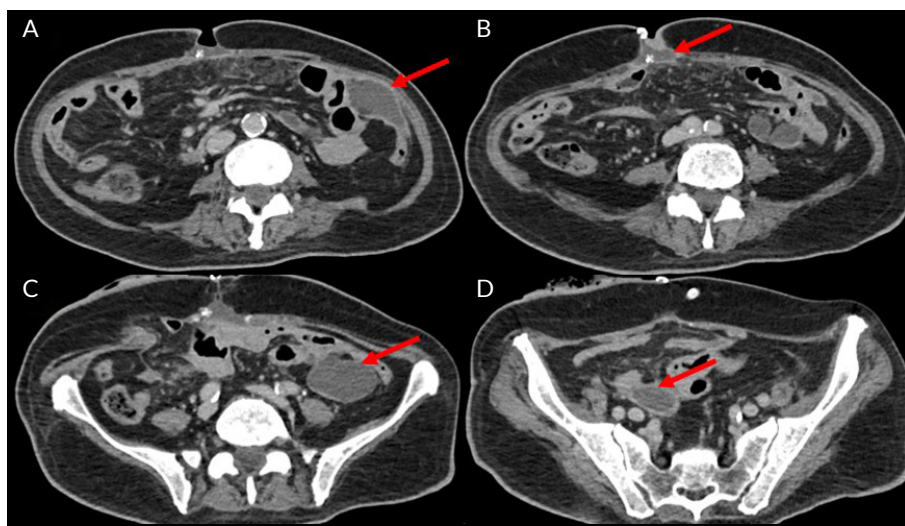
Axial computed tomography scan with contrast demonstrating (A) a rim-enhancing fluid collection in the left lower abdomen (red arrow), (B) a skin wound on the anterior abdominal wall along the midline with a drainage catheter terminating at the superior aspect of the wound as well as with diffuse edema of the mesenteric fat (red arrow), (C) a rim-enhancing fluid collection in the left pelvis (red arrow), and (D) a rim-enhancing fluid collection in the deep right pelvis (red arrow).
